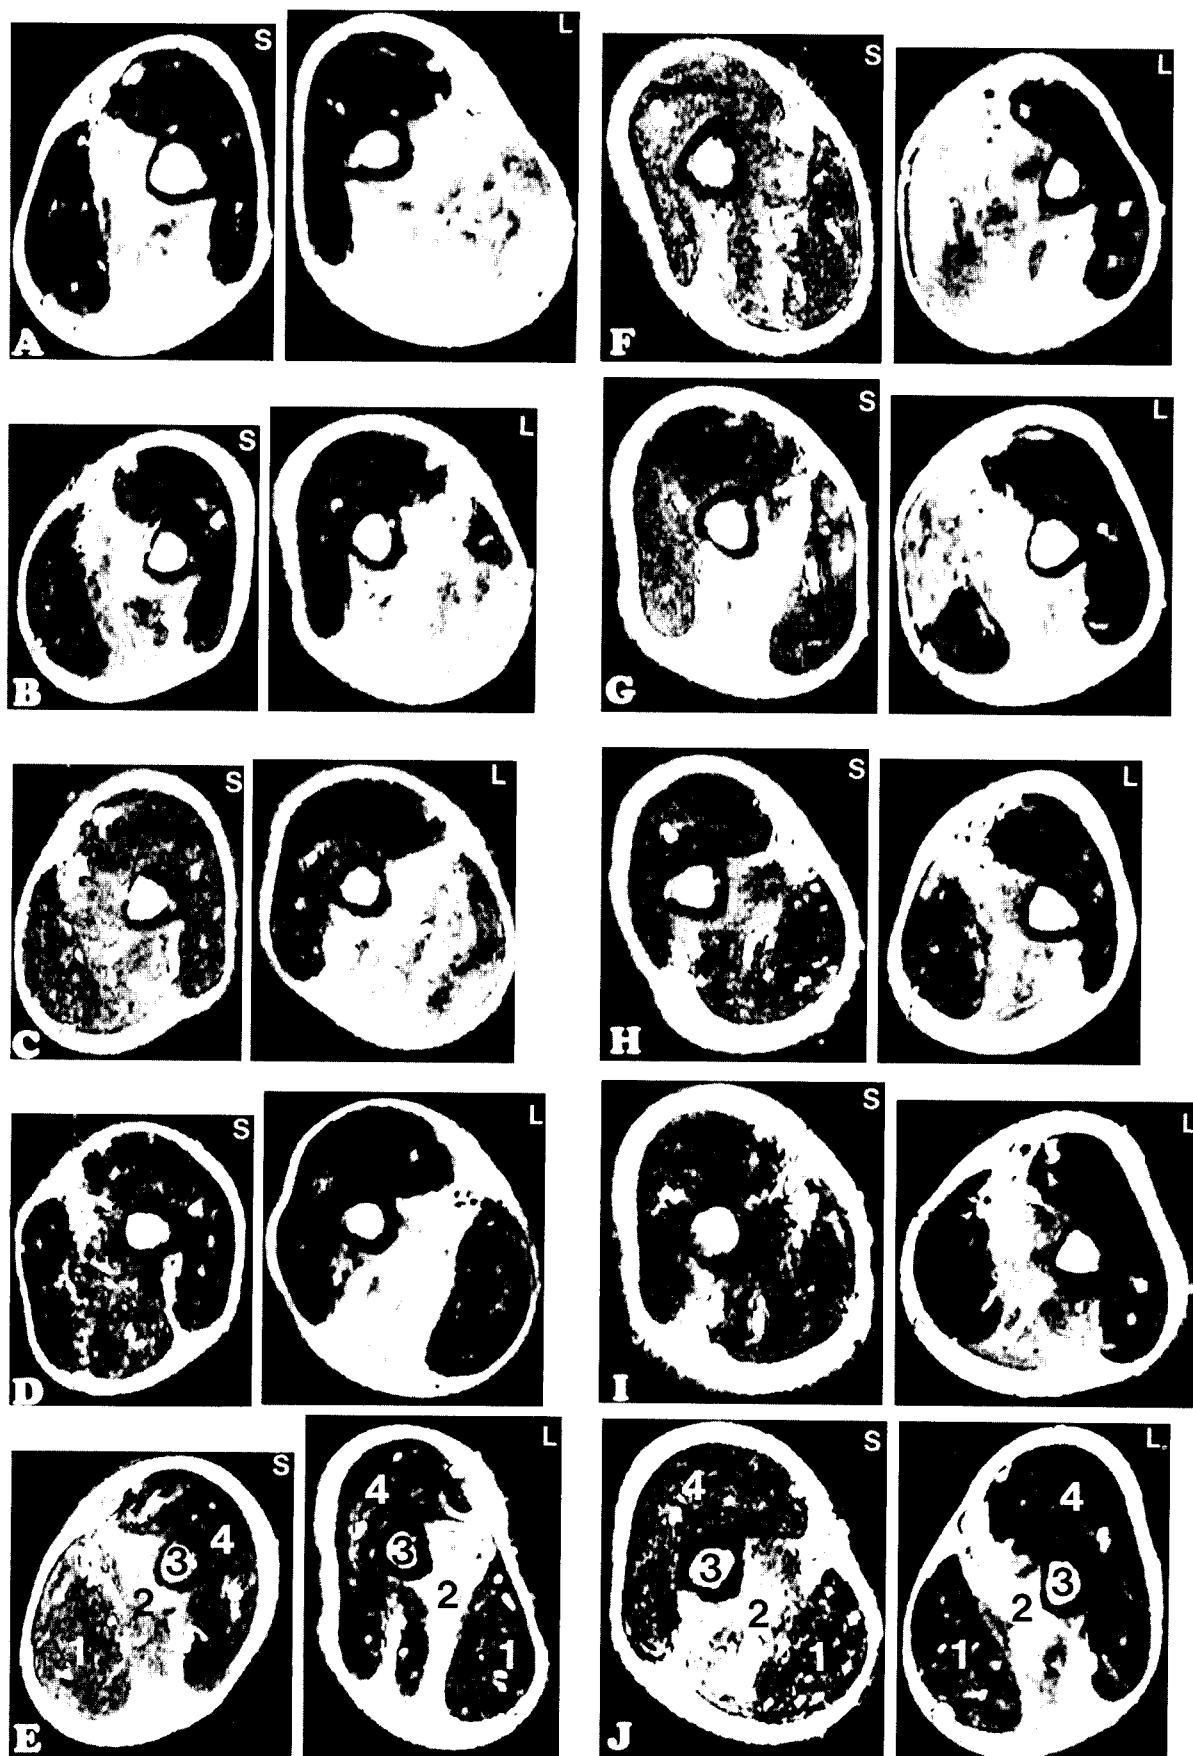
T2 MR images of 10 subjects (A–J) after eccentric exercise in the *S* and *L* conditions. Compared with the *S* condition, more conspicuous abnormality in the brachialis is seen in the *L* condition. Some subjects (A, B, C, F, G) showed abnormality in the biceps brachii as well in the *L* condition. 1: biceps brachii, 2: brachialis, 3: humerus, 4: triceps brachii.
